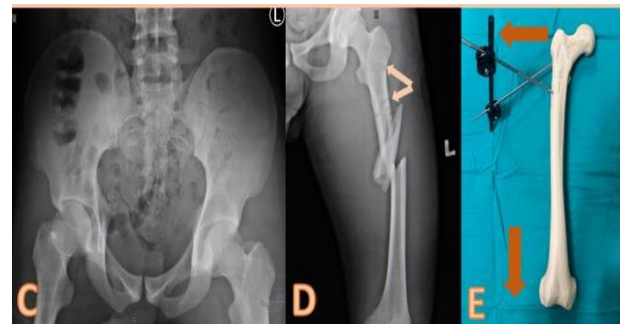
Plain radiography of pelvis (AP view) shows successful reduction of left hip
